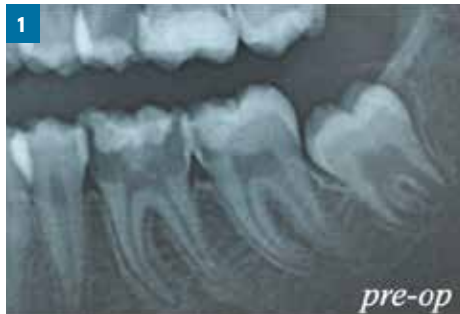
Preoperative radiographs showing unrecoverable tooth 36 and unerupted tooth 38 with incomplete root formation
